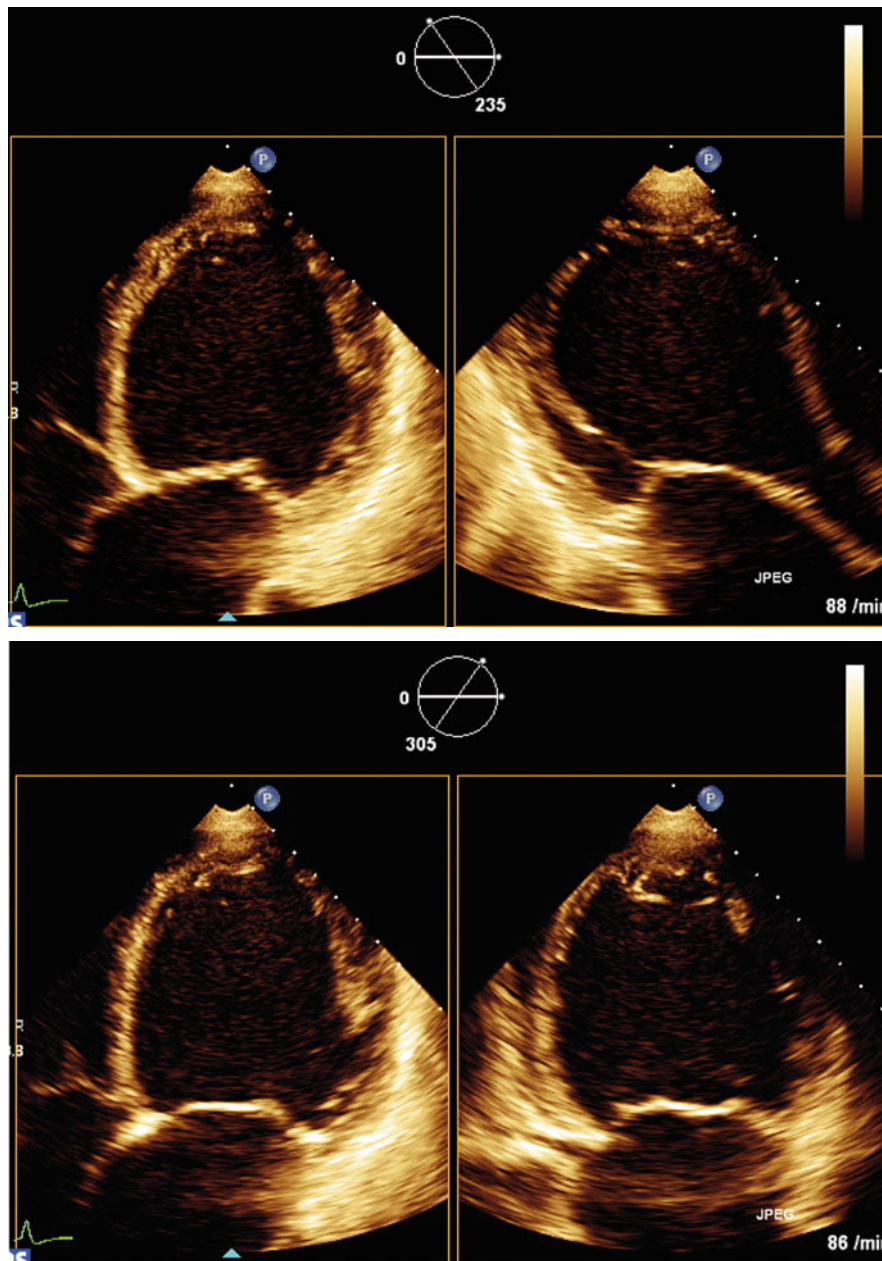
Electronic rotation of 2D image planes during the stress echocardiographic protocol using the xPlane mode. *Top* The image shows simultaneously a 4-chamber view (*top left*) and at 235° rotation a long-axis view (*top right*). The electronic rotation of the right image relative to the left is indicated by the rotation symbol on top. *Bottom* Without rotating the matrix array transducer, the image plane on the right can be electronically rotated. Here a standard 2-chamber view is shown at 305° rotation. During a stress echocardiographic protocol, identical image plane rotations can be easily reproduced at any protocol step. [→Videos 4.2A,B]
